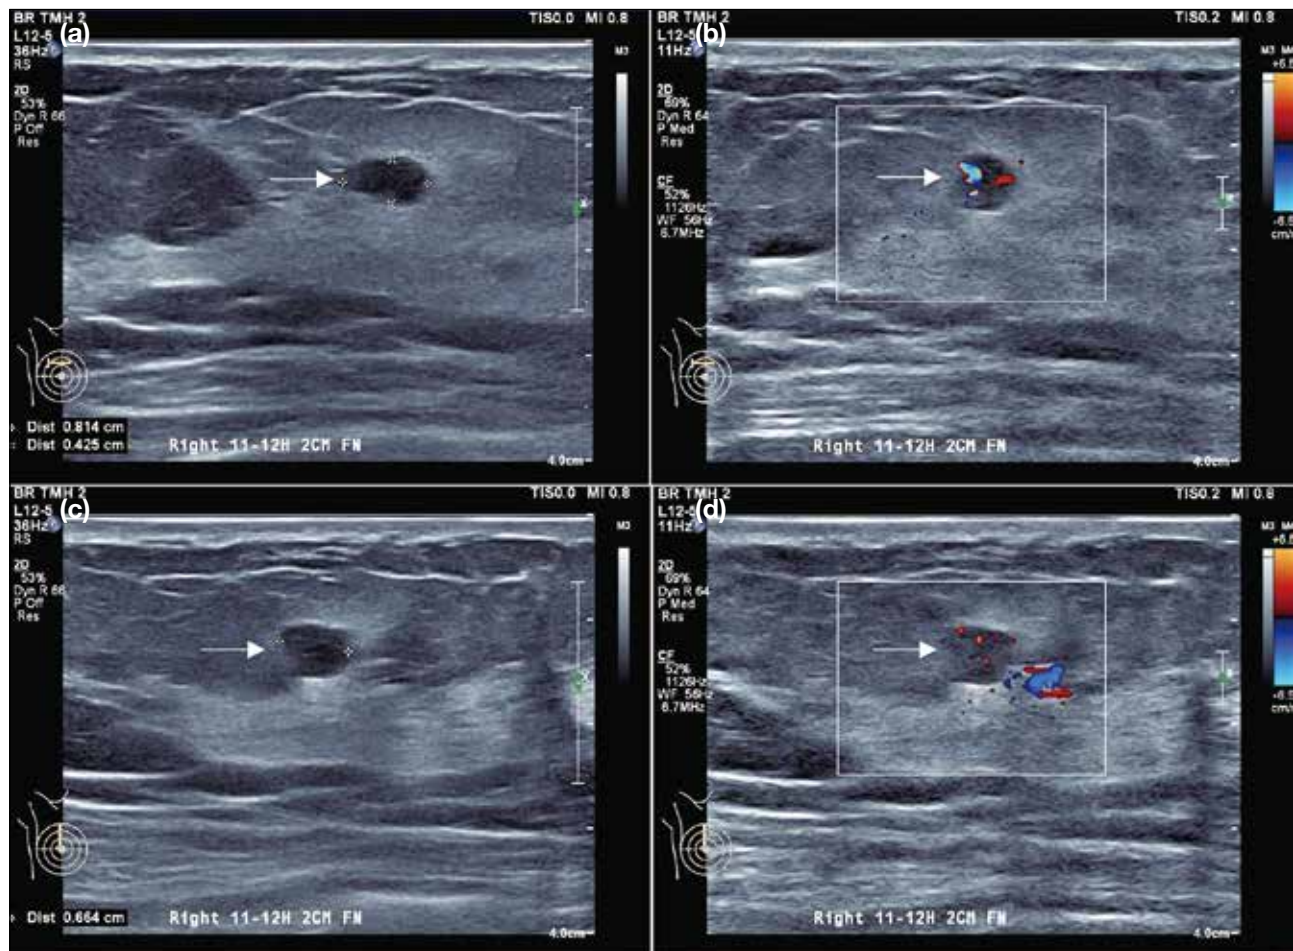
Another case of haemangioma. Ultrasound of the right breast (arrows in [a] and [c]). At the 11-12 o'clock position, 2 cm from the nipple, a $0.8 \times 0.4 \times 0.7$ cm³ oval, hypoechoic mass is seen, oriented parallel to the tissue planes, with microlobulated margins. Internal vascularity is demonstrated on Doppler ultrasound (arrows in [b] and [d]).
